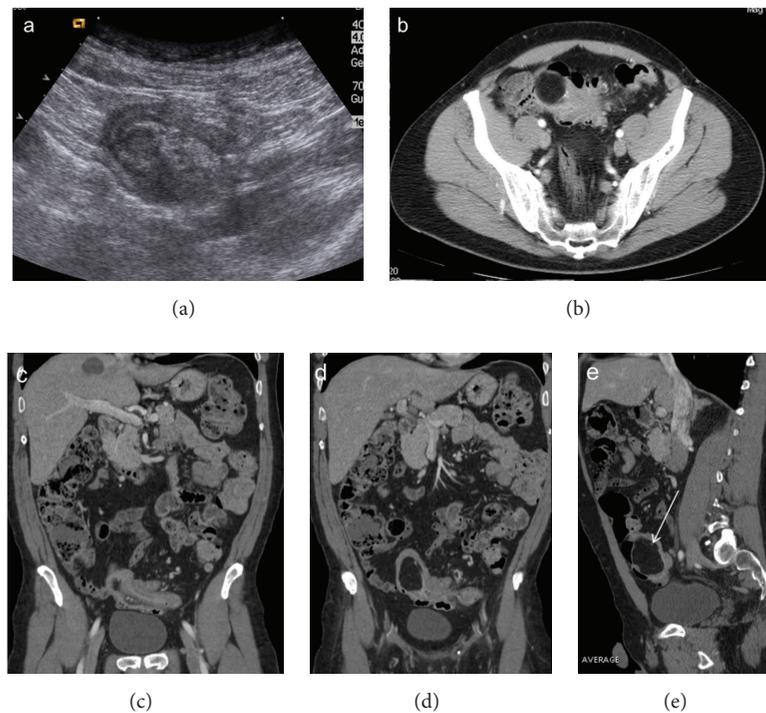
Colocolonic (sigmoid) intussusception caused by a lipoma. Ultrasound scan (a) shows a pelvic layered ovoid mass. CT images on axial (b) and oblique reformatting (c, d, e) demonstrate an intraluminal lesion with fat attenuation (arrow) that serves as the intussusception lead point.
